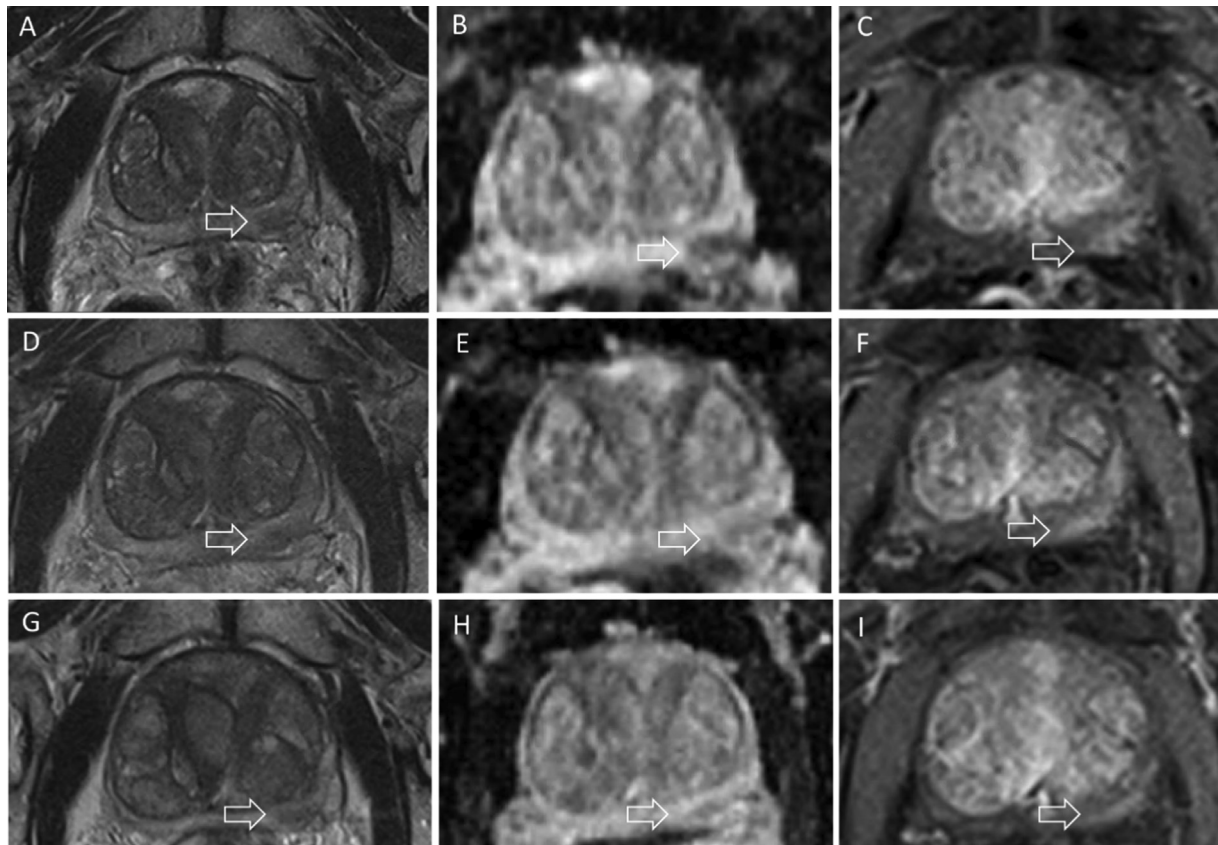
Magnetic resonance images of a 73-yr-old patient presenting with prostate-specific antigen (PSA) of 5.6 ng/ml. Baseline images show a Prostate Imaging-Reporting and Data System 4/5 lesion (arrows) in the left peripheral zone at midgland on (A) T2-weighted imaging, (B) on the apparent diffusion coefficient map from diffusion-weighted imaging and (C) on dynamic contrast-enhanced sequences. Targeted biopsy revealed Gleason 3 + 3 disease in two out of four cores involving 40% of the cores. The patient opted for active surveillance. Subsequent prostate magnetic resonance images at (D–F) 1 yr and (G–I) 5 yr show the stability of the lesion on all sequences along with relatively stable PSA findings (6.7 and 6.5 ng/ml, respectively). The patient is still on active surveillance and was biopsied only after baseline imaging.
